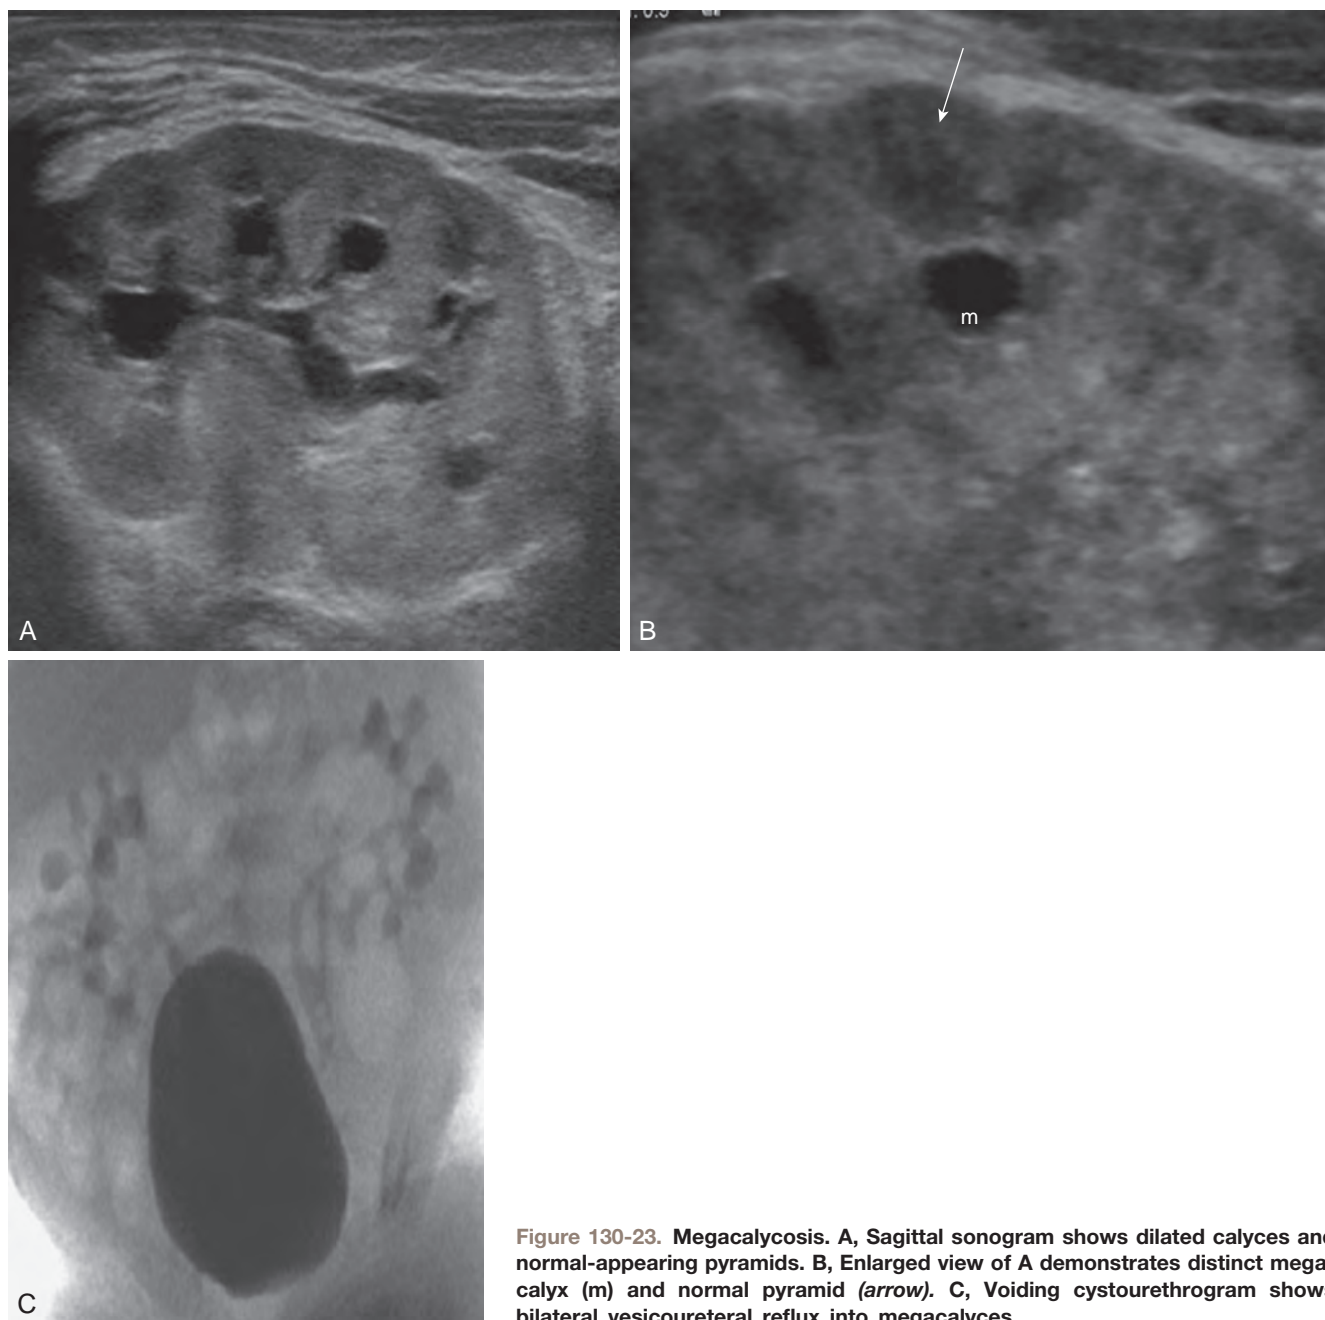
Megacalycosis. A, Sagittal sonogram shows dilated calyces and normal-appearing pyramids. B, Enlarged view of A demonstrates distinct megacalyx (m) and normal pyramid (arrow). C, Voiding cystourethrogram shows bilateral vesicoureteral reflux into megacalyces.
